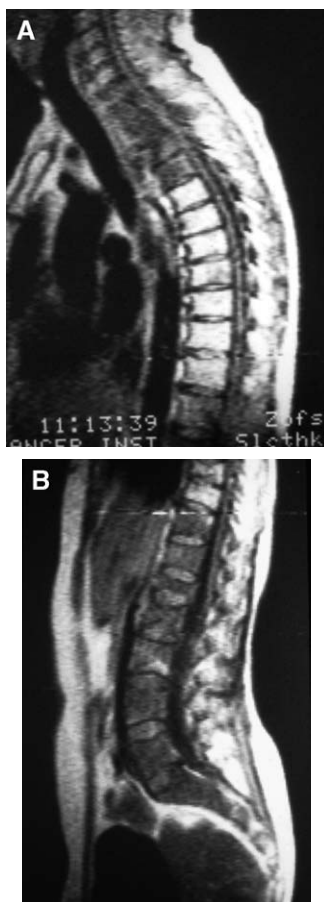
MRI showing multiple adjacent levels of involvement: cervical (A) and lumbar (B).
